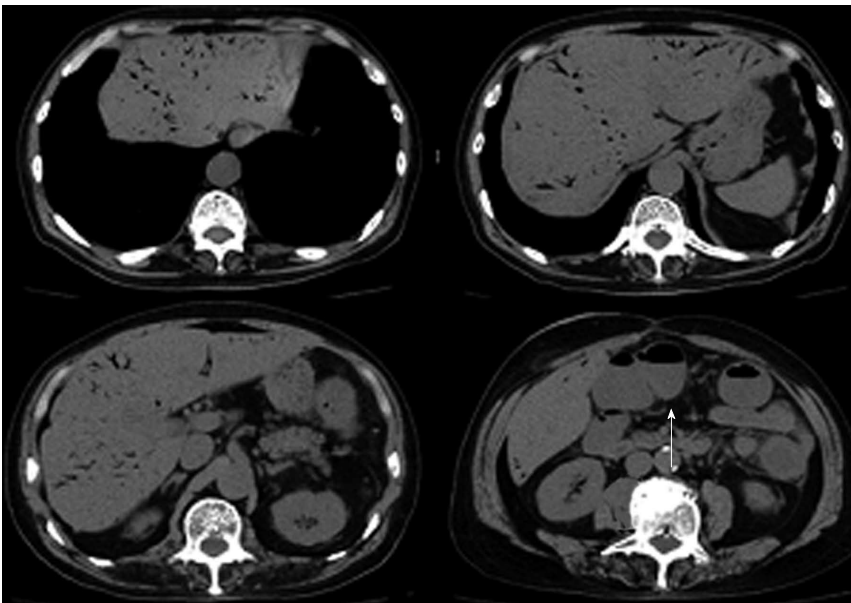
Computed tomography scan of the abdomen showed a marked amount of air throughout the portal venous system. The transverse colon was dilated (arrow).
